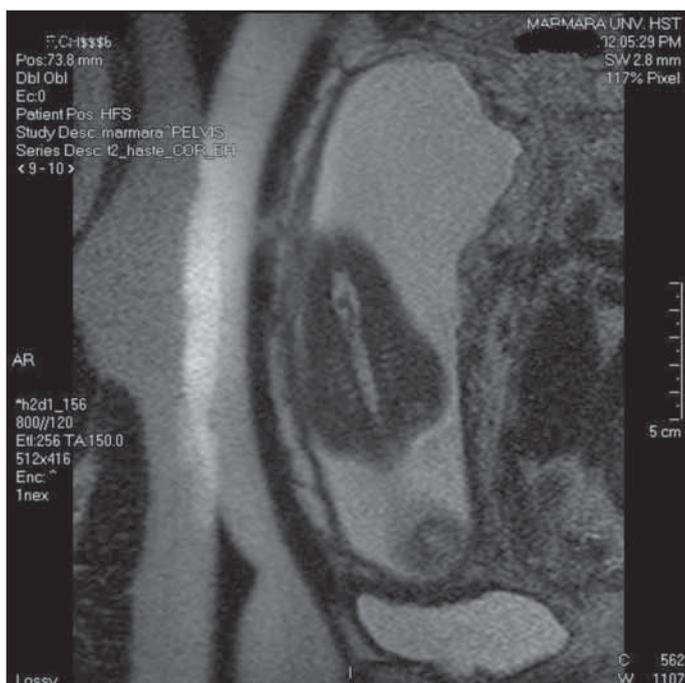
MRI of the fetal spine in Case 2. The bony spur in the lumbosacral junction
